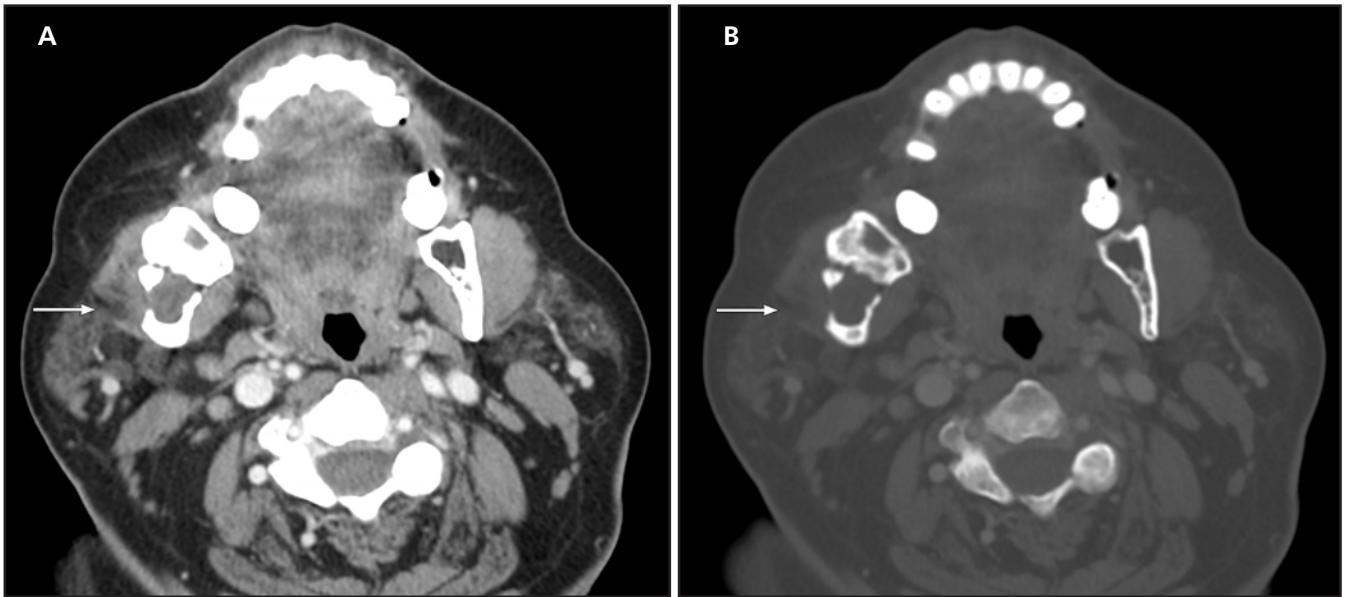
Axial CT images obtained after intravenous administration of contrast are displayed in soft tissue (A) and bone windows (B). There is a nonenhancing, lytic, and expansile lesion involving the right mandibular ramus with areas of cortical thinning/dehiscence in addition to other areas of sclerotic thickened cortex. The lesion extends to the mandibular condyle resulting in subluxation of the temporomandibular joint.
